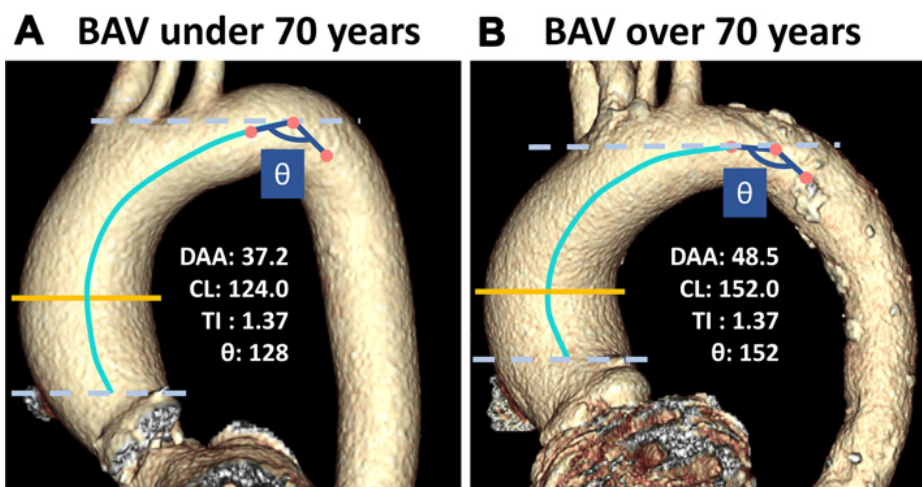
Representative three-dimensional model CT images of BAV patients aged < 70 years and \geq 70 years old. A: BAV < 70 years. B: BAV \geq 70 years. Older BAV patients had greater diameter and elongation of the ascending aorta and obtuse angle of the aortic arch compared with younger age patients. TI, tortuosity index; θ , the minimum angle of the aortic arch.
